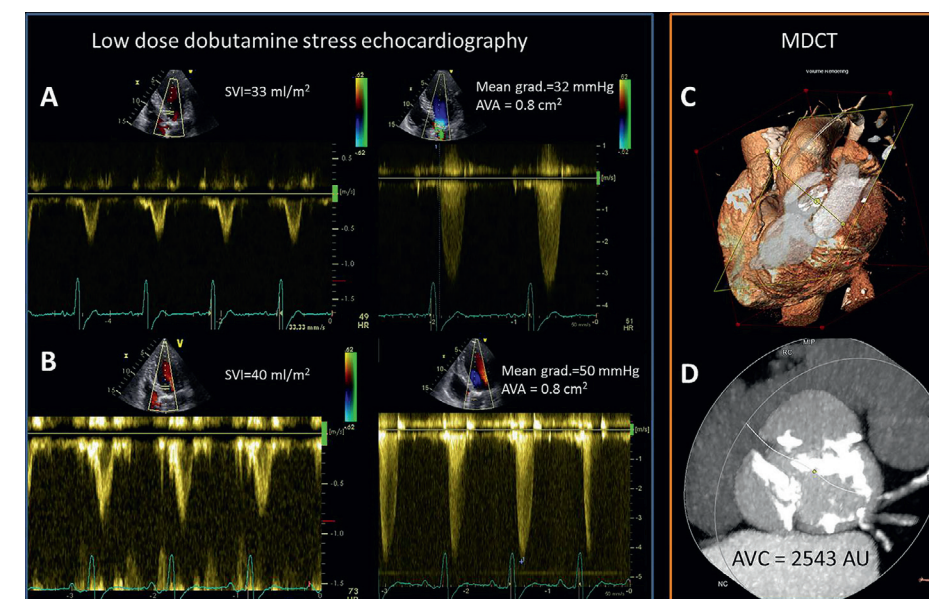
Low-dose dobutamine stress echocardiography (DSE) and aortic valve calcification (AVC) assessment with multidetector row computed tomography (MDCT) in a patient with low-flow low-gradient severe aortic stenosis (AS) with reduced left ventricular systolic function. (A) Baseline echocardiographic assessment revealed discrepant indices of AS severity. The mean gradient was 32 mm Hg and aortic valve area (AVA) was 0.8 cm². Stroke volume index (SVI) of 33 mL/m². (B) Low-dose DSE resulted in an increase of the mean gradient to 50 mm Hg, the AVA remained unchanged and the SVI increased by 21%. This indicates that the patient had classical low-flow low-gradient severe AS and a presence of flow reserve (SVI increased $>20\%$). (C) Volume rendered cardiac MDCT with a plane across the aortic annulus. (D) AVC load, using the Agatston method, was measured 2543 arbitrary units (AU), indicating severe aortic stenosis (cut-offs for severe AS $\geq 2,065$ AU in men and $\geq 1,274$ AU in women¹⁴).
